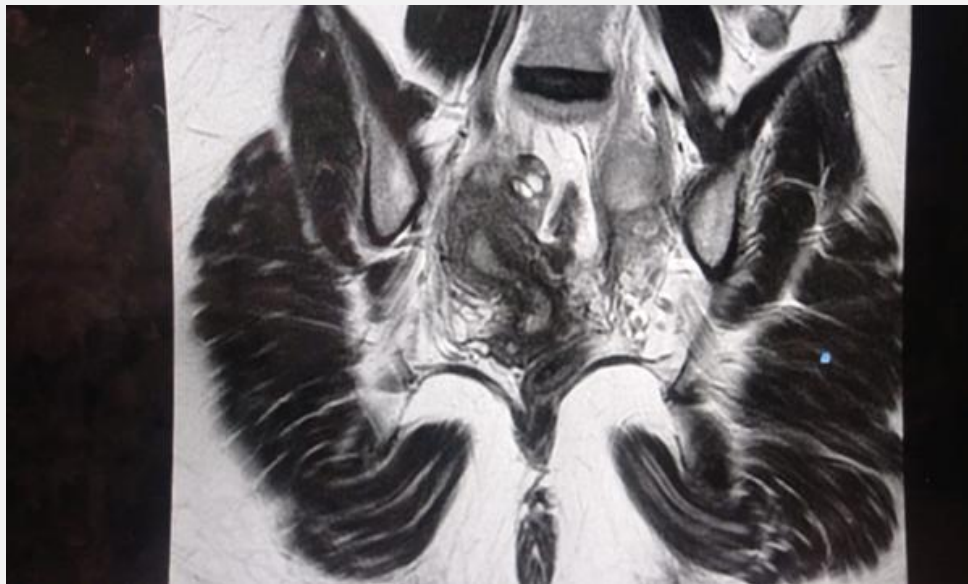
Coronal image of MRI pelvis showing right-sided uterine horn
